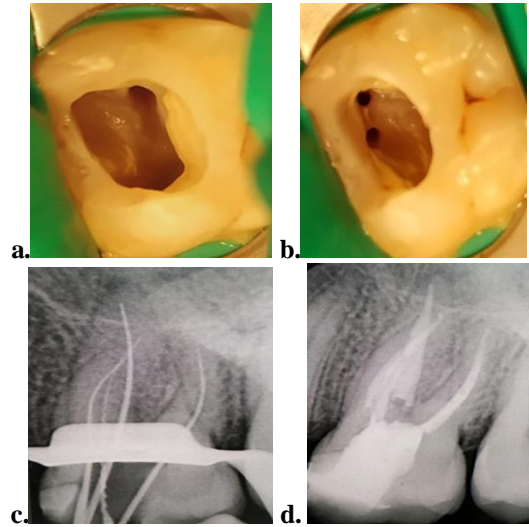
Representing Type II canal configuration in the mesiobuccal root. A and b. Photograph of access cavity, c. Working length determination x-ray, d. Post-obturation x-ray
